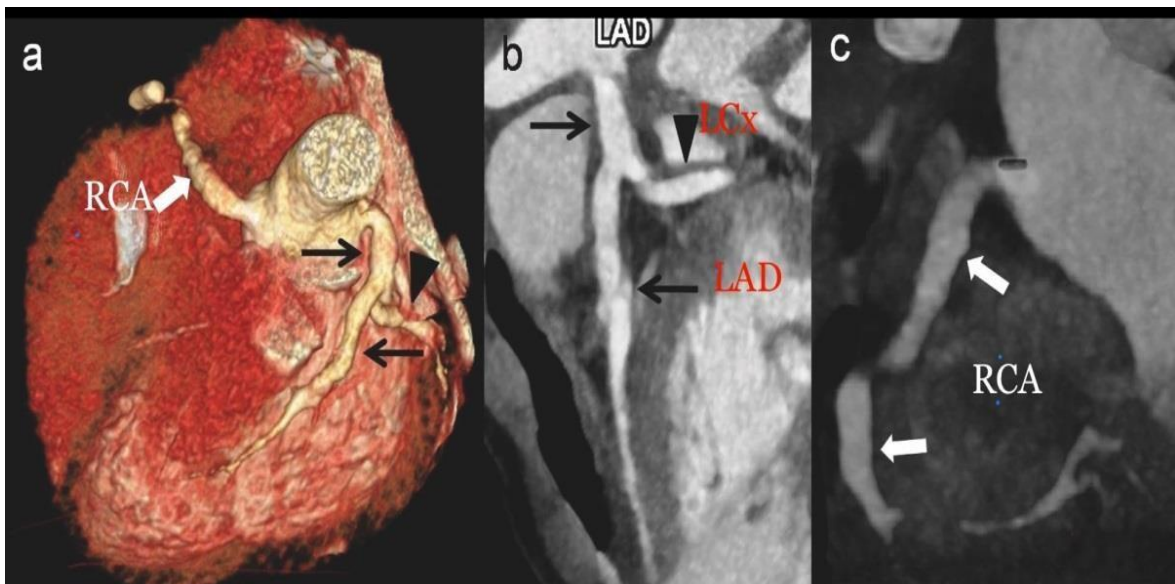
CT coronary angiography showing coronary aneurysms findings in the patient.
